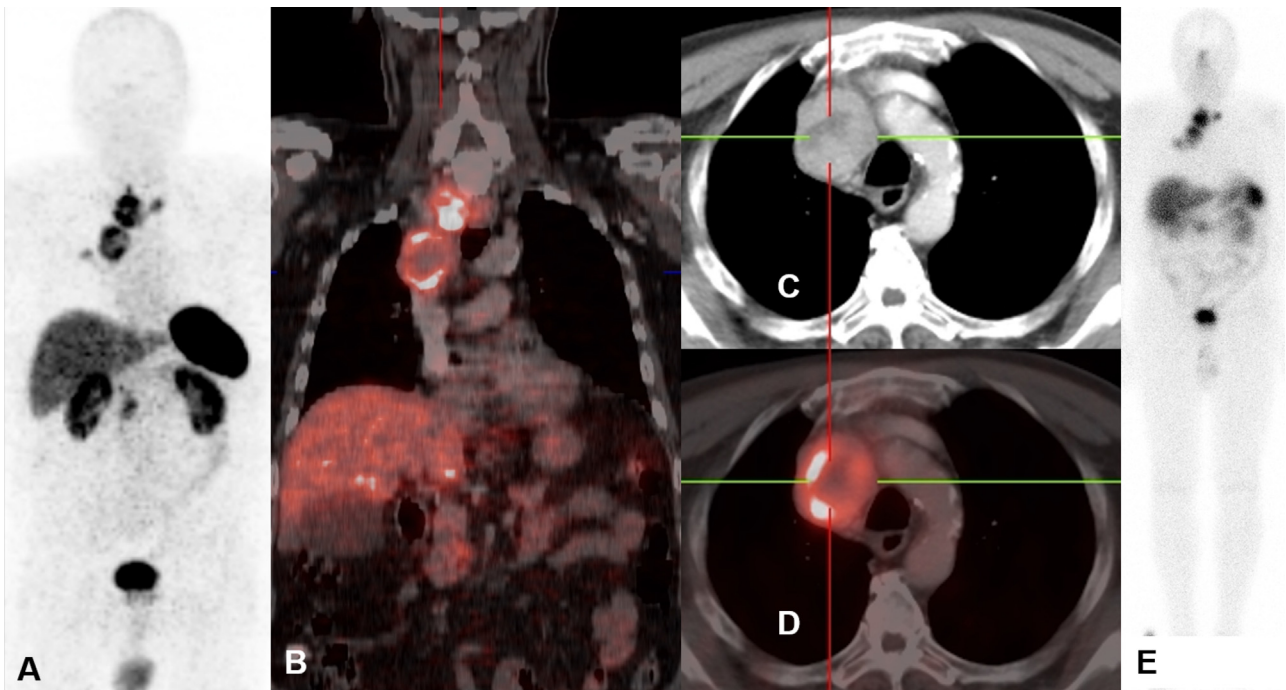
Partial remission of the disease (described in Figure 3) after just one cycle with increasing necrosis, especially in the mediastinal lymph node mass demonstrated by decreasing uptake on follow-up ^{68}Ga -DOTATOC PET/CT (A-D). The patient underwent another cycle of PRRT with ^{177}Lu -DOTATOC, which demonstrated uptake at these sites (E).
